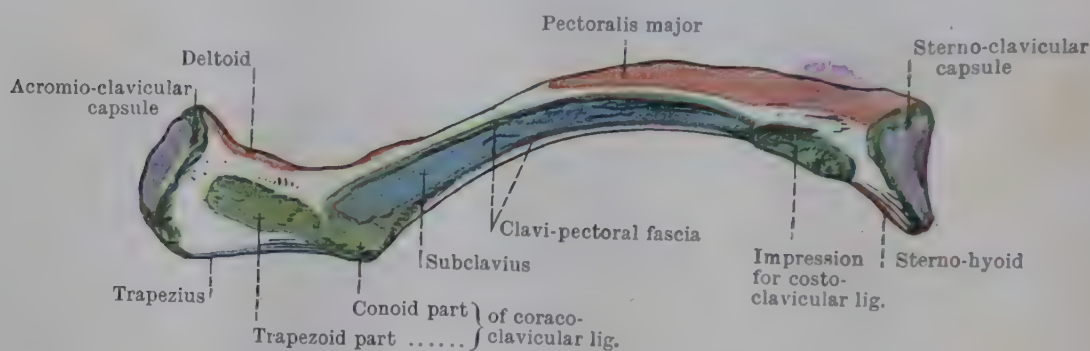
INFERIOR ASPECT OF RIGHT CLAVICLE.
